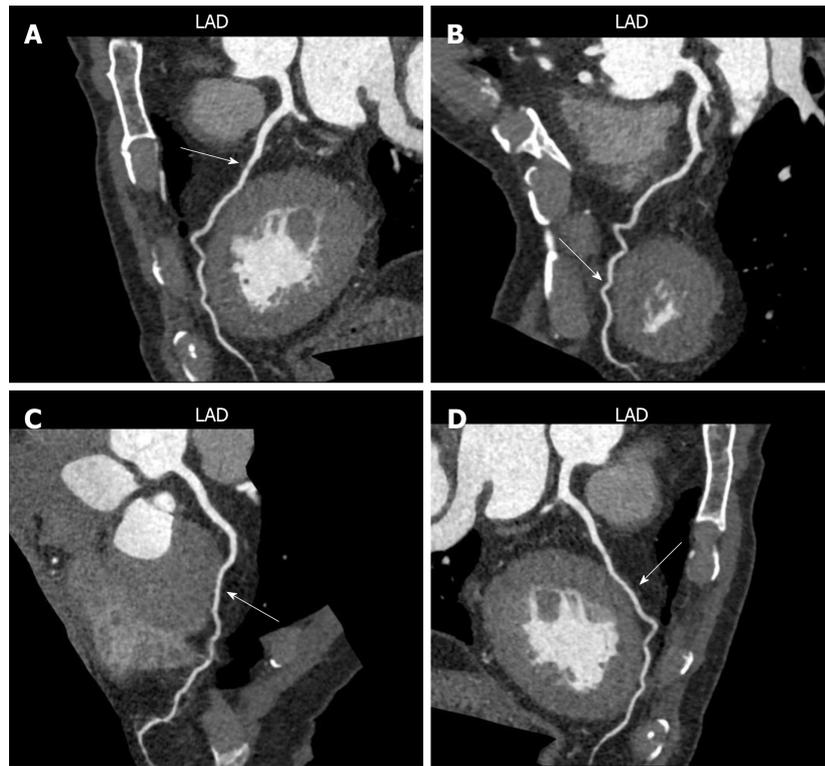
Computed tomography coronary angiography images of myocardial bridge lesions. Myocardial bridge (MB) was marked by the arrow in figures. A and B: MB in the left anterior descending coronary artery; C: MB in the anterior descending coronary artery; D: MB in the right anterior descending coronary artery.
